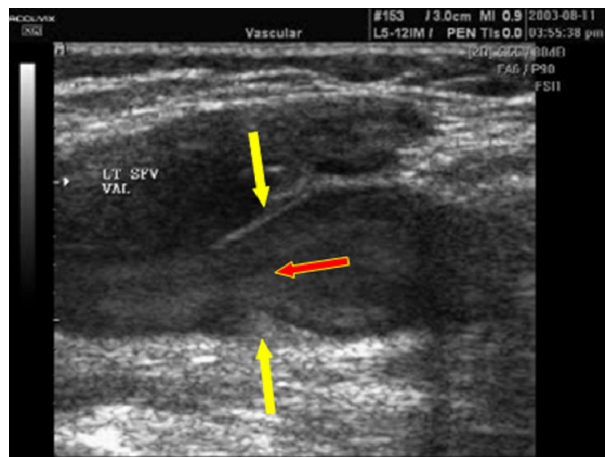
The ejection phenomenon (red arrow) between the valves (yellow arrows) (natural contrast echo Doppler).
